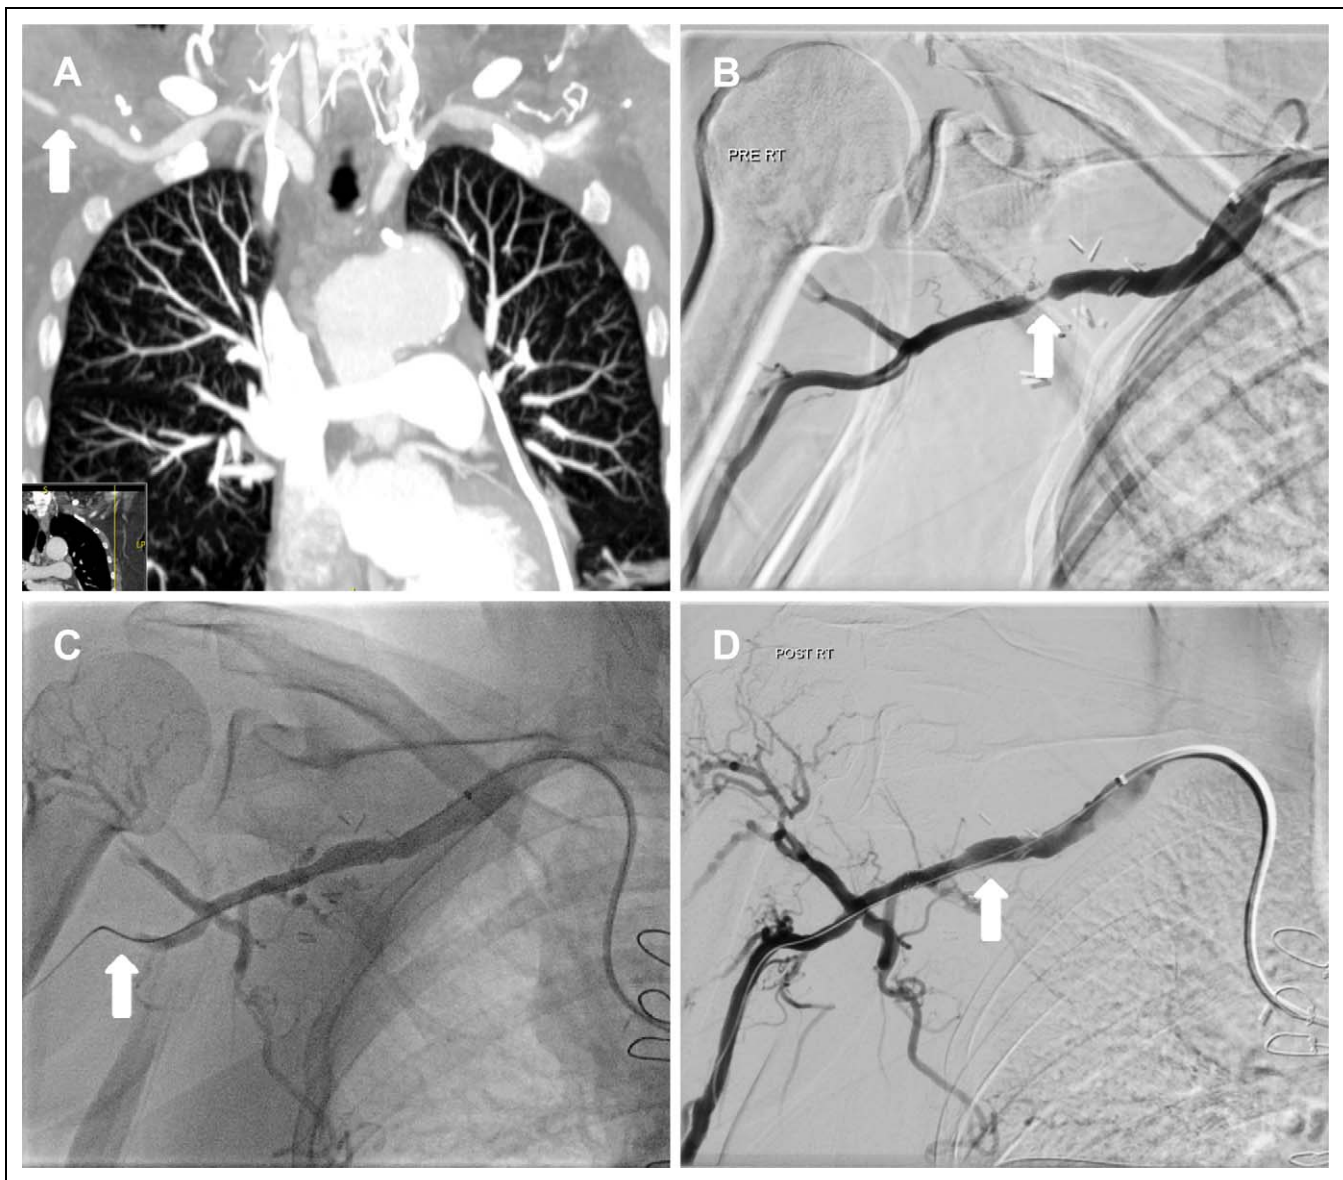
A, Coronal computed tomography (CT) angiography demonstrating a high-grade lesion in the right axillary artery. B, Selective angiography demonstrating critical focal stenosis in the right axillary artery at the distal edge of the prior Dacron interposition graft. Bridging collaterals are present. C, Angiographic still frame demonstrating interruption of antegrade arterial flow with right arm suprasystolic blood pressure cuff inflation. D, Selective subclavian angiography indicating excellent final result after placement of self-expanding stent and postdilation.
